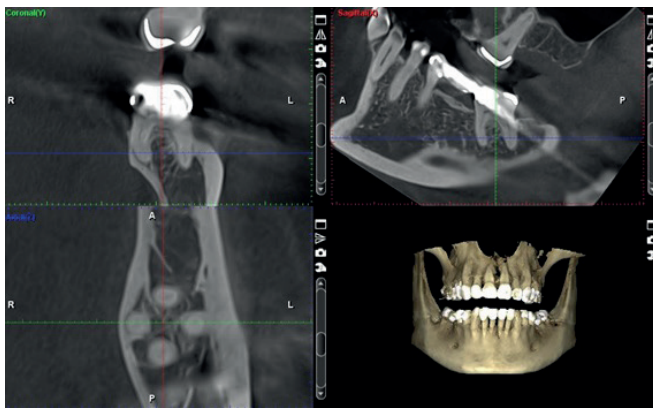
Cone-beam computed tomography: a) coronal projection performed on the buccal and lingual roots; b) sagittal projection performed on the mesial and distal roots of 37 teeth. c) axial projection showing the formed root system 37 of the tooth in the form of a regular rhombus.
